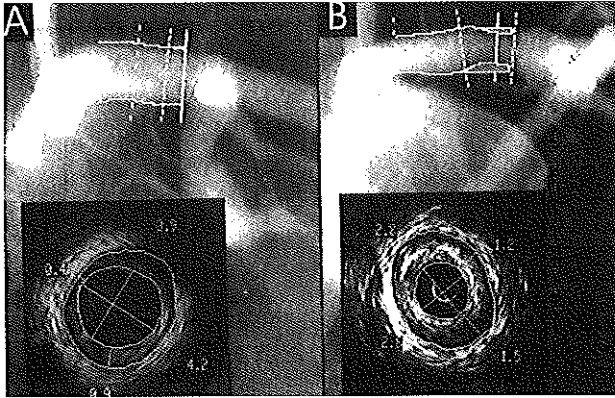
Examples of plaque formation in left main coronary arteries without (A) and with (B) luminal narrowing on the angiogram. The angiograms display the plaque interpolation and minimal lumen detection, as obtained from quantitative coronary angiography. The intravascular ultrasound images (inserts) depict the site of minimum lumen cross-sectional area; on these images the contours of the lumen and total vessel boundaries as well as the minimum and maximum diameters of lumen and plaque + media were traced.
